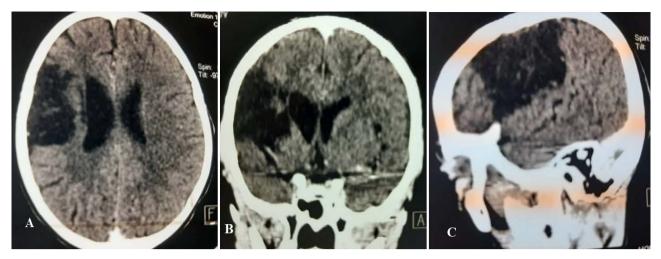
Brain CT in axial section (A); coronal (B) and sagittal reconstruction (C) without contrast product objectifying a ischemic stroke with formation of a porencephalic cavity of the superficial and deep territory of the right sylvian and of the homolateral anterior junctional territory.
